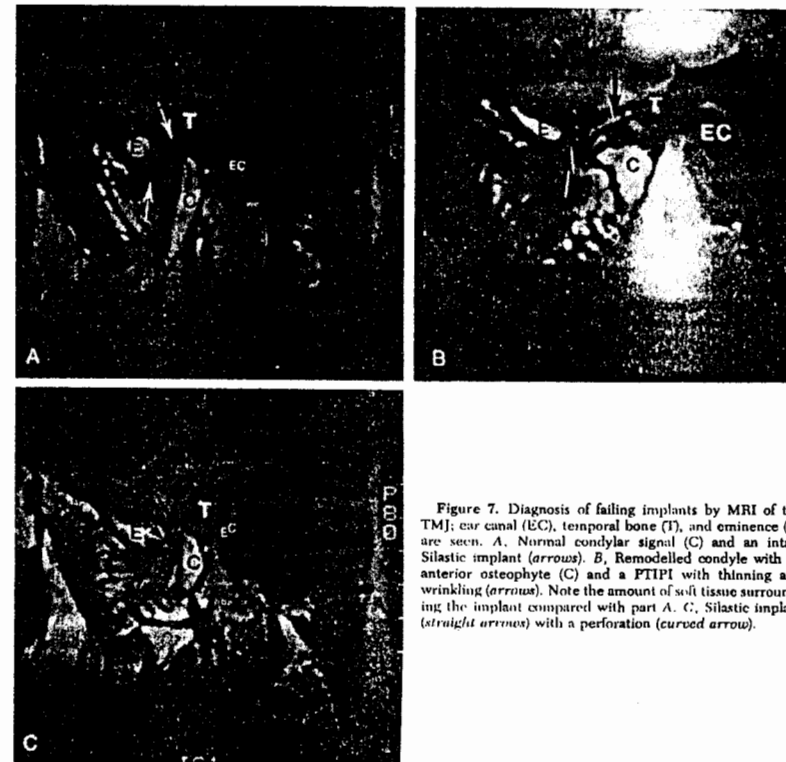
Diagnosis of failing implants by MRI of the TMJ: ear canal (EC), temporal bone (T), and eminence (E) are seen. A, Normal condylar signal (C) and an intact Silastic implant (arrows). B, Remodelled condyle with an anterior osteophyte (C) and a FTIPI with thinning and wrinkling (arrows). Note the amount of soft tissue surrounding the implant compared with part A. C, Silastic implant (straight arrows) with a perforation (curved arrow).
